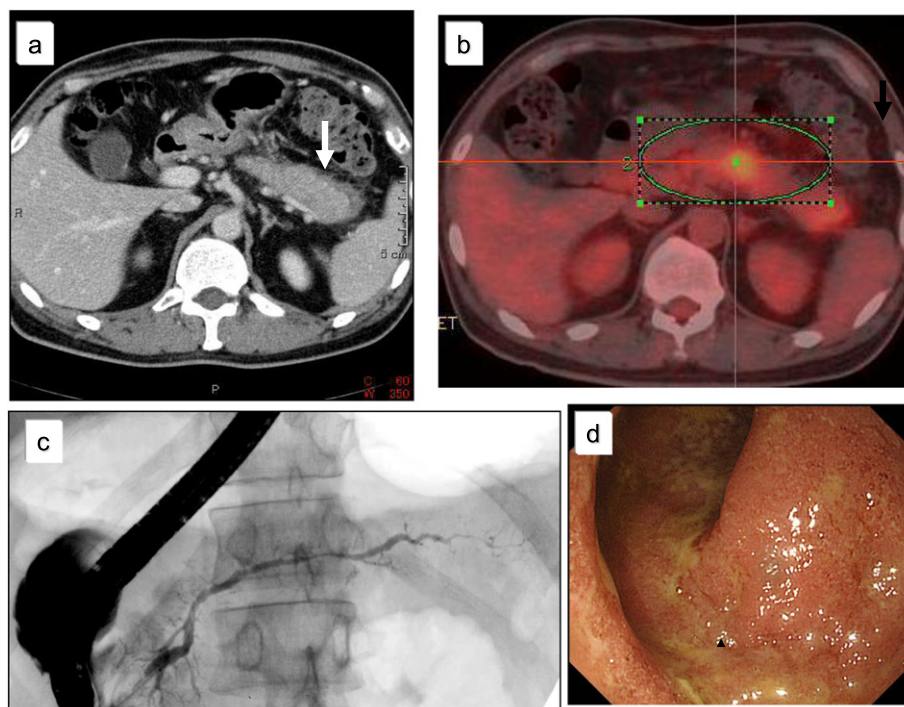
Type 2 AIP. a. Dynamic CT shows diffuse swelling of the pancreas with late phase enhancement and low-density rim (arrow) similar to type 1 AIP. b. PET-CT shows diffusely abnormal accumulation of FDG. c. Endoscopic pancreatography shows irregular narrowing of the main pancreatic duct. d. Colonoscopy shows proctitis type of ulcerative colitis.
